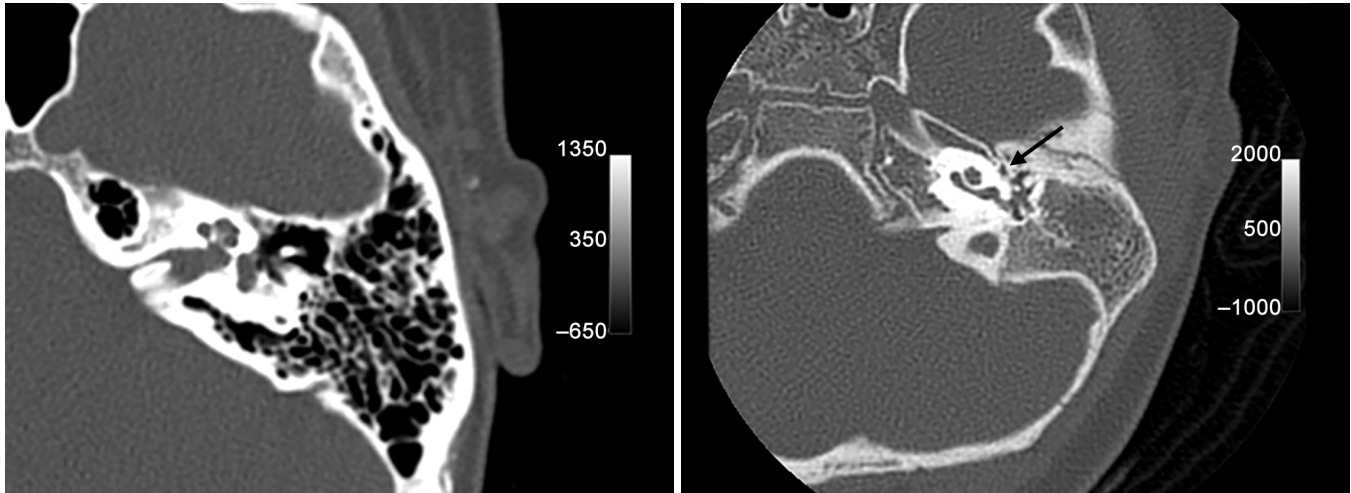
High-resolution coronal CT scans demonstrating an excellent candidate for atresiaplasty in the left panel and a poor candidate in the right panel. Note abnormal position of facial nerve on promontory of cochlea (arrow) in poor candidate and limited aeration of mastoid and middle ear.
